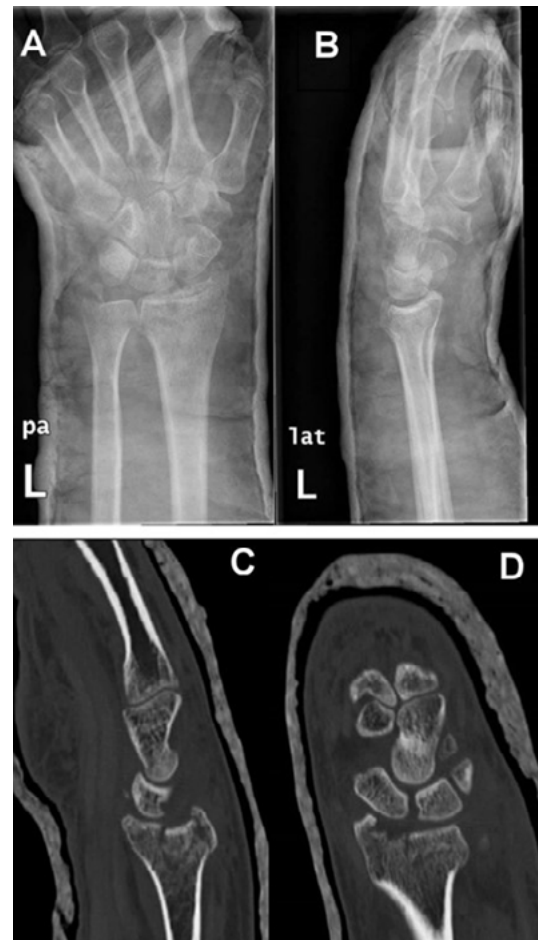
Preoperative planning images of described patient with an intra-articular distal radius fracture. AP (A) and lateral (B) of left wrist radiographs after reduction and immobilization with cast; CT scan with coronal (C) and sagittal (D) views is made before surgery treatment for better determination of articular affection more than 1 mm step-off.
